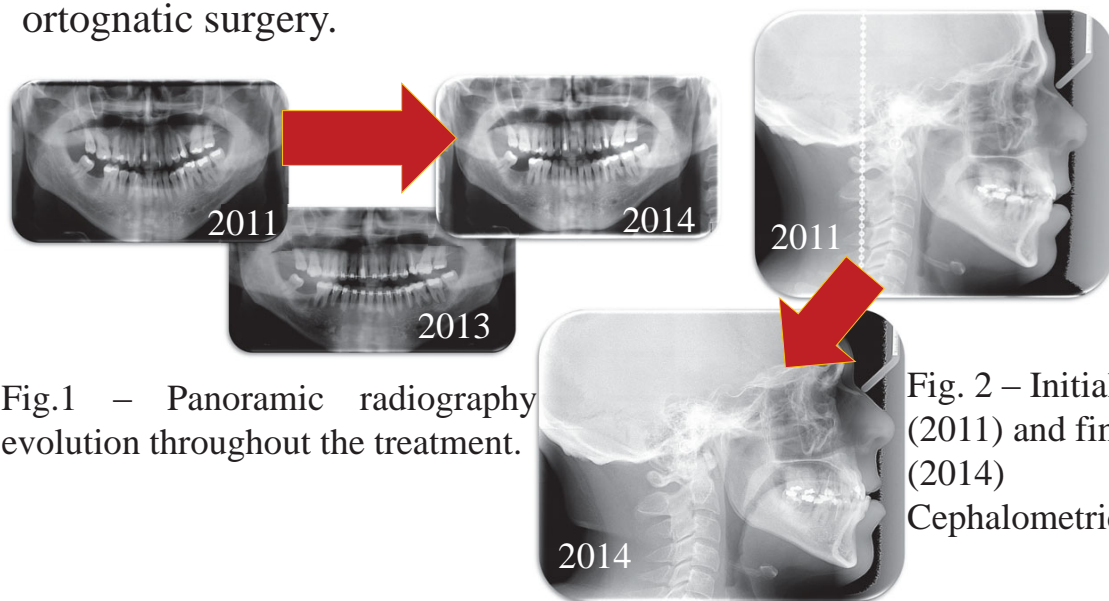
Panoramic radiography evolution throughout the treatment.
